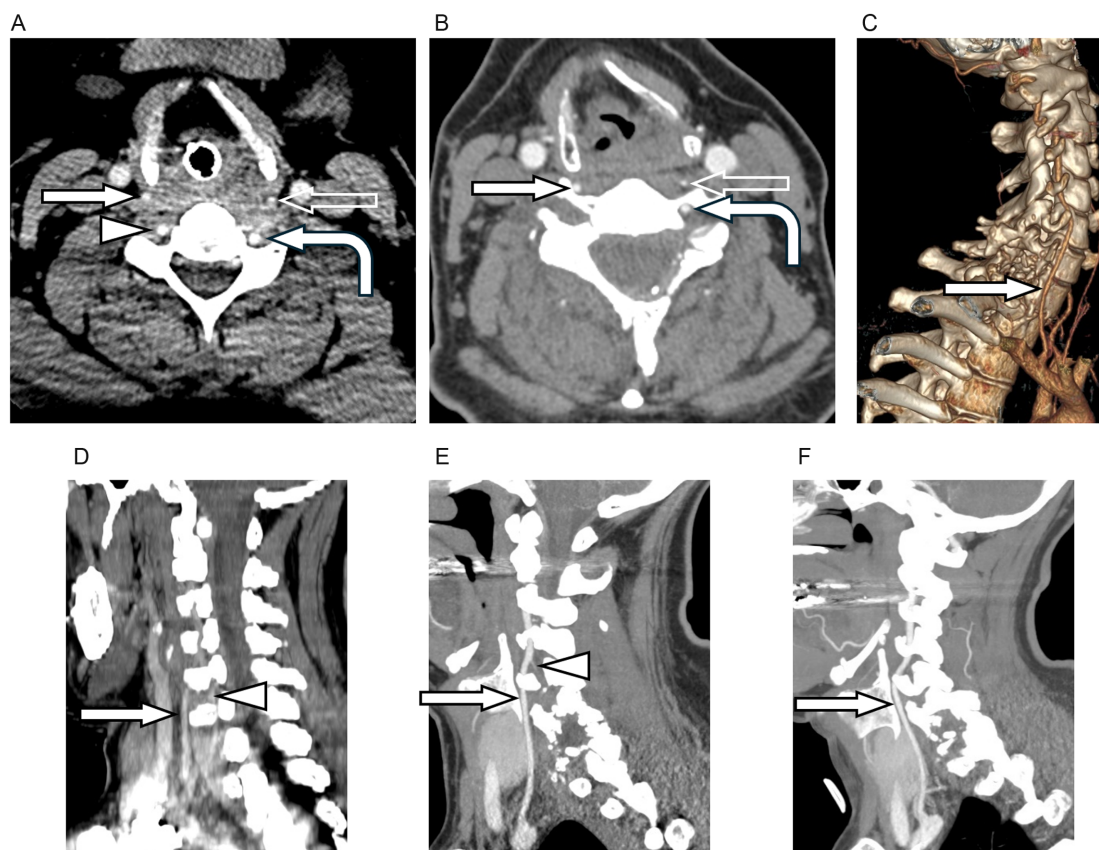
(a) Contrast enhanced axial CT before gunshot injury showing the right anterior branch (solid white arrow), right posterior branch (white arrowhead), left anterior branch (empty white arrow), and left posterior branch of the vertebral arteries (curved white arrow); (b) CT angiogram after gunshot injury showing non-opacification of the right posterior branch; (c) 3D reconstruction of the right vertebral artery after gunshot injury; (d) contrast enhanced sagittal oblique CT before gunshot injury showing the anterior and posterior branches of the right vertebral artery; (e) sagittal oblique CT angiogram after gunshot injury showing acute dissection of the right posterior vertebral artery with trace contrast opacification at C4-C5 (white arrowhead) and patent anterior branch of the right vertebral artery; (f) sagittal oblique CT angiogram 3 months after gunshot injury showing complete non-opacification of the posterior branch of the right vertebral artery.
